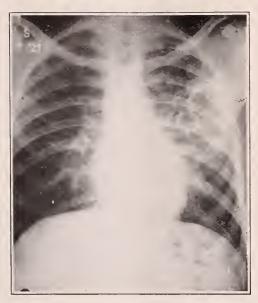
Case IV. Roentgenogram of October, 1927, showing large cavity in upper left lung field (a), with surrounding exudative density.
